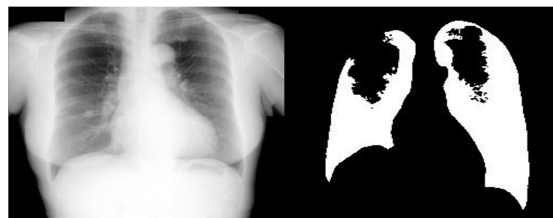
showing x-ray of patient and detected malignant tumour
